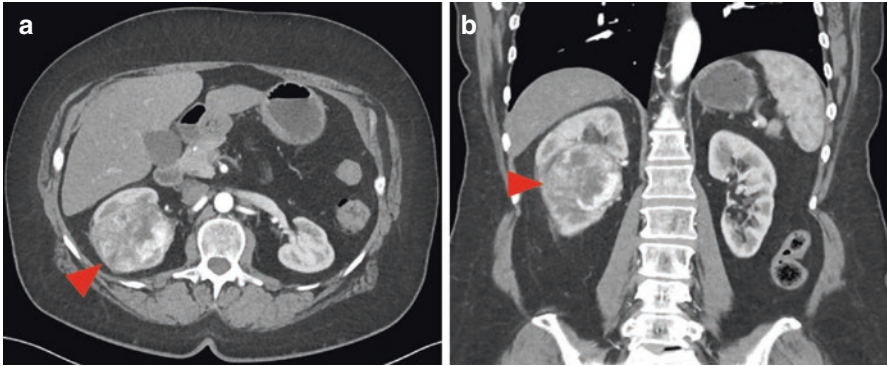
CT images of a clinically localized clear cell RCC. (a) Axial and (b) coronal, arterial phase images. Note the brisk arterial enhancement in this tumor (red arrowheads) particularly along the inferomedial aspects of the lesion. This enhancement pattern is typical for clear cell RCC
